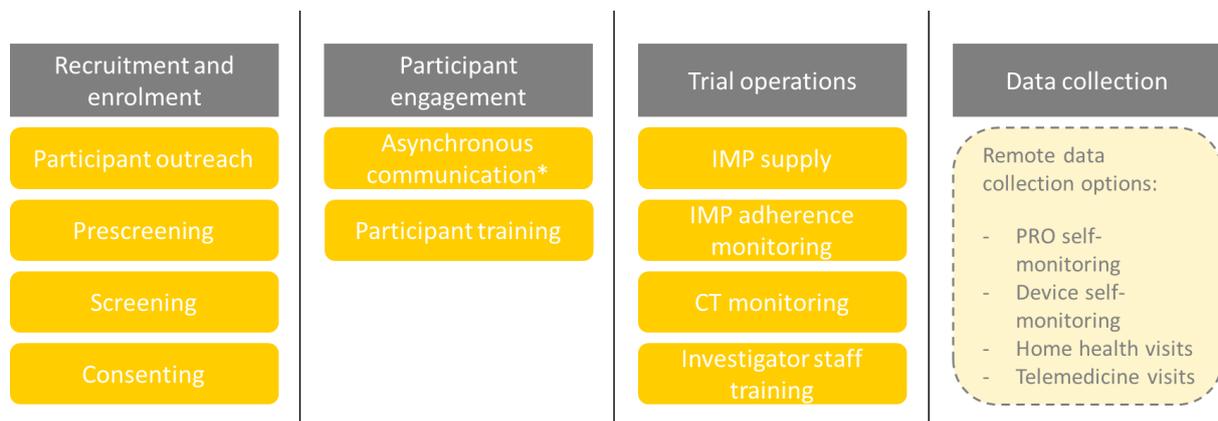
Summary of the classification matrix. Remote and/or on-site conduct of each of the in the yellow presented trial activities was coded for, with the exception of asynchronous communication as this is remote only (by definition). Four options for remote data collection were used. Abbreviations: CT, clinical trial; IMP, investigational medicinal product; PRO, participant-reported outcome.
